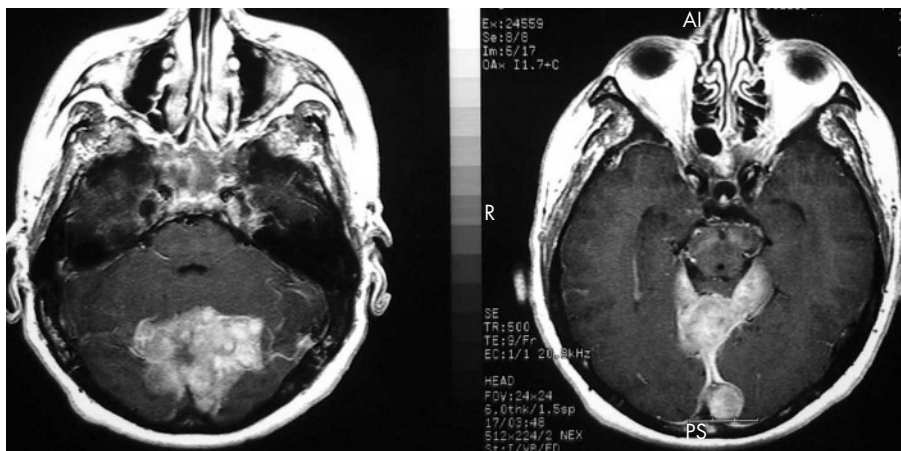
Brain MRI axial T1-weighted postcontrast image shows abnormal homogeneous infratentorial tumour at the level of the torcula.
